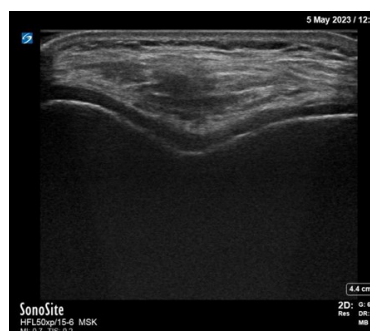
Typical ultrasound image of normal cartilage.
